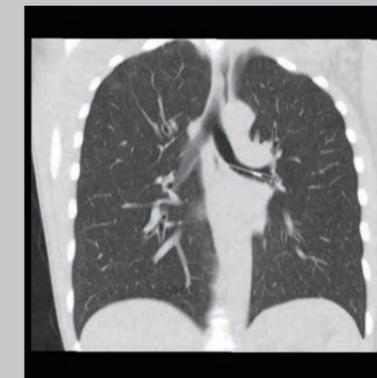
Ultra-low-dose chest CT. 0.1 mSv - 35-year-old woman IVDU. Needle in LM bronchus. DLP 6.
